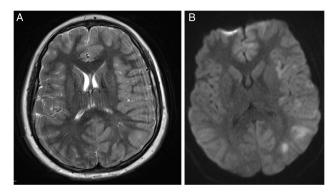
(A) Axial T2 -weighted MRI image showing left cerebral hemisphere edema. (B) Axial diffusion-weighted imaging image showing patchy cortical and subcortical areas of restricted diffusion in the left cerebral hemisphere. Imaging quality is significantly degraded by patient movement artifact.
